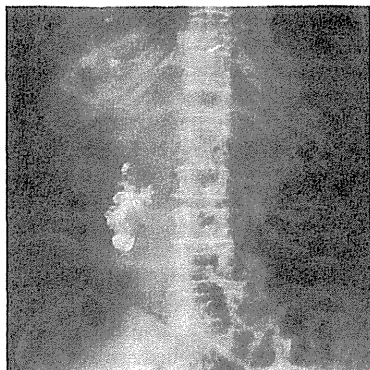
Radiograph after embolization of the duodenal varices demonstrates complete and adequate accumulation of the ethiodized oil in the varices.
